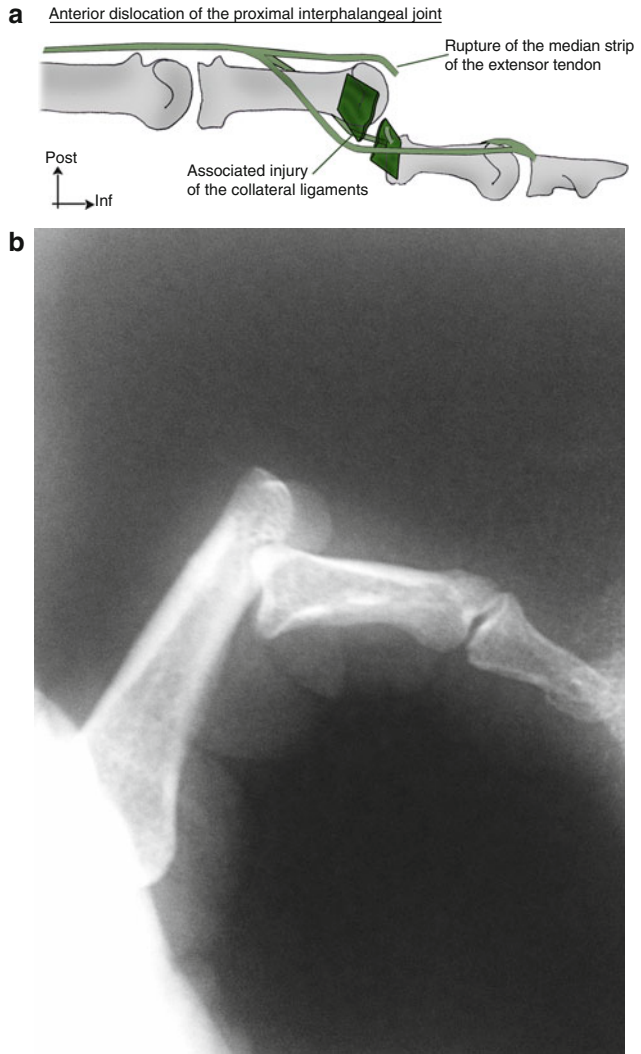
Anatomical injuries in a palmar dislocation (a) and radiography (b)
